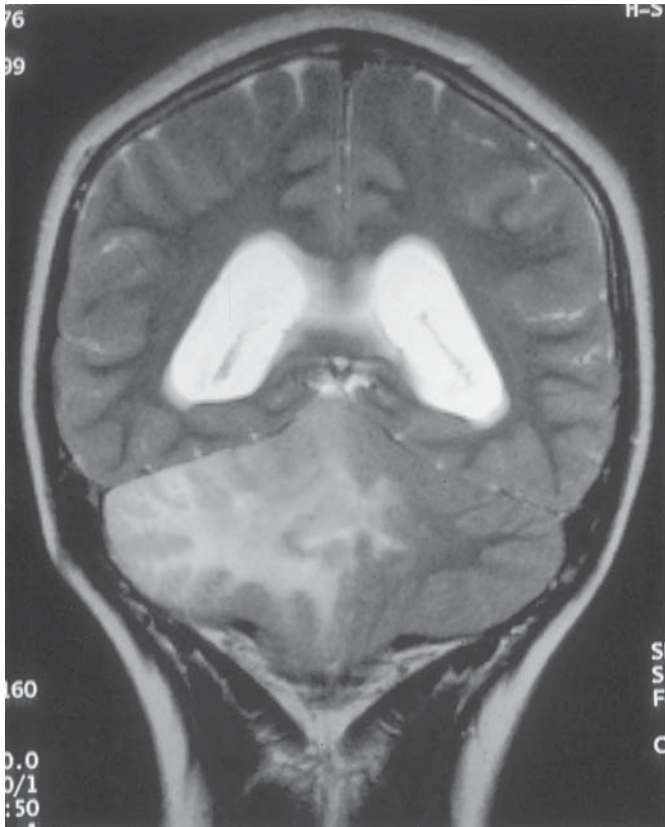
Large right cerebellar anaplastic astrocytoma resulting in obstructive hydrocephalus (T2-weighted MR scan). The patient had undergone radiotherapy for a nasopharyngeal rhabdomyosarcoma 18 yr prior to the diagnosis of the current tumor.
